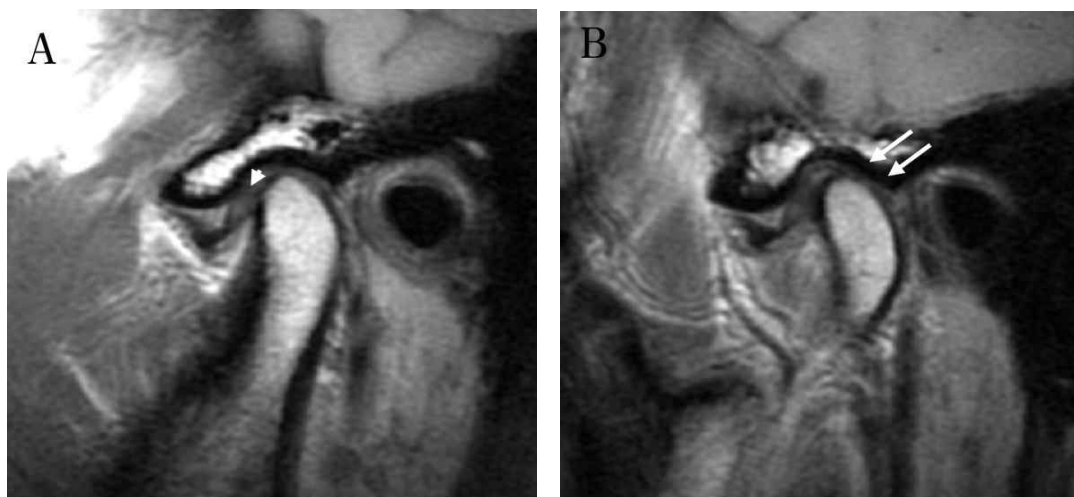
Pre-treatment proton density weighted magnetic resonance images of right TMJ in closed jaw position. A: midsagittal cross-sectional view. White arrowhead indicates the distal end of displaced disc. B: slightly medially cross-sectional view. Two white arrows indicate the collapse of posterior articular cavity.
